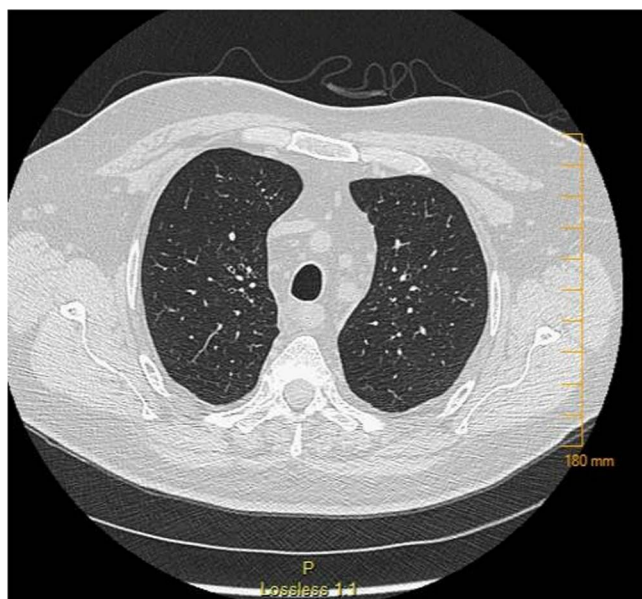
CT scan after treatment showing resolution of symptoms.
